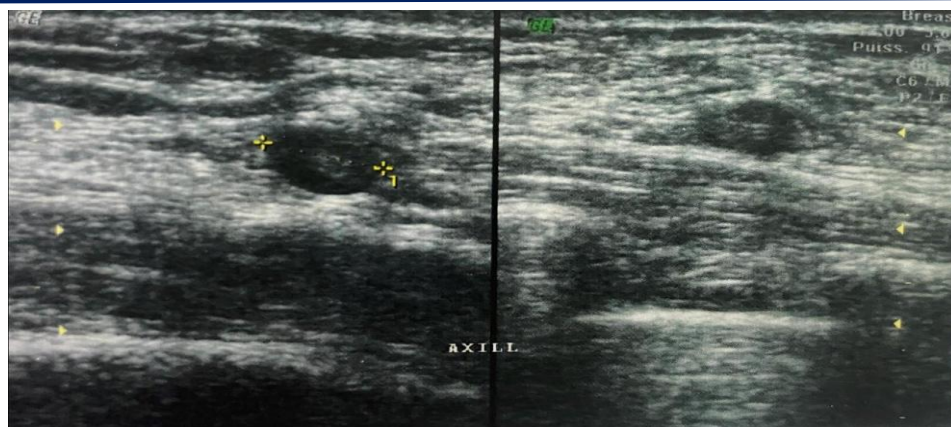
Ultrasound appearance of the tumor
